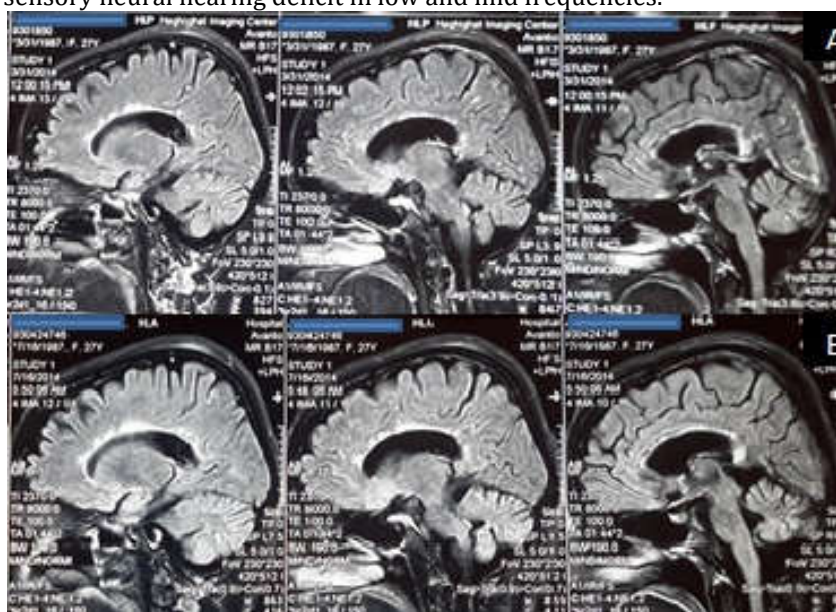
Sagittal T2-weighted MR image shows hyper intense of the corpus callosum. A: march2014 - B: four month later
